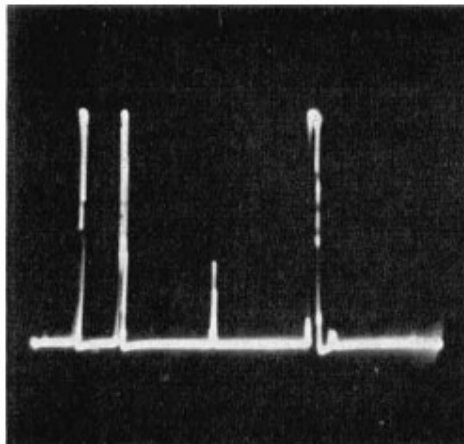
Typical A-mode display demonstrating high amplitude signals from the fetal skull. The first peak represents the strong echo from the maternal abdominal wall. The following high amplitude peaks represent echoes from the parietal bones, with a low amplitude peak representing the interhemispheric fissure positioned midway between these (from Campbell S. An improved method of fetal cephalometry by ultrasound. *The Journal of obstetrics and gynaecology of the British Commonwealth*. 1968;75(5):568-76. Reproduced with permission Copyright © 2005 John Wiley & Sons Ltd. All rights reserved.)
